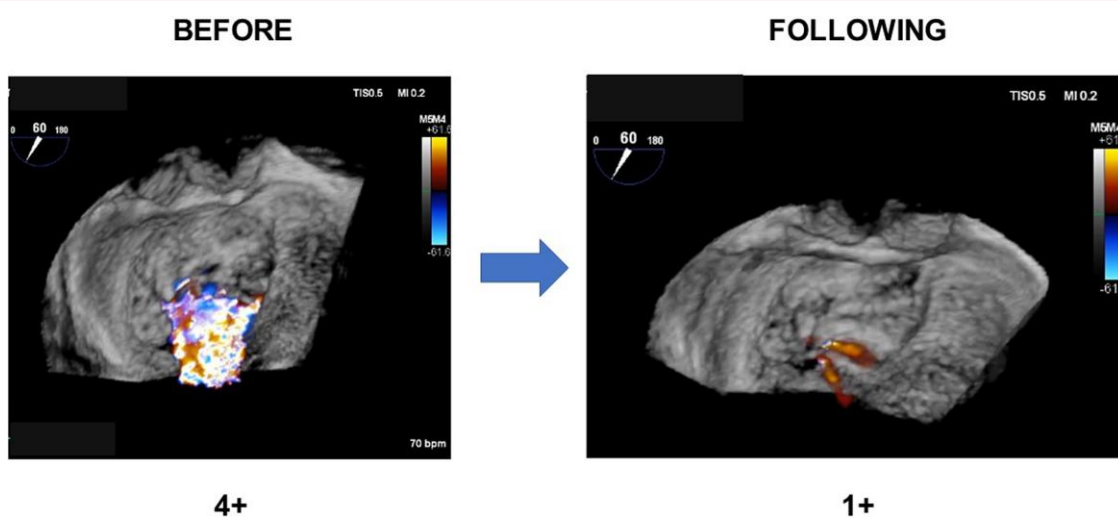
Transoesophageal echocardiographic findings before and following Impella-assisted transcatheter edge-to-edge repair in Patient 1.
